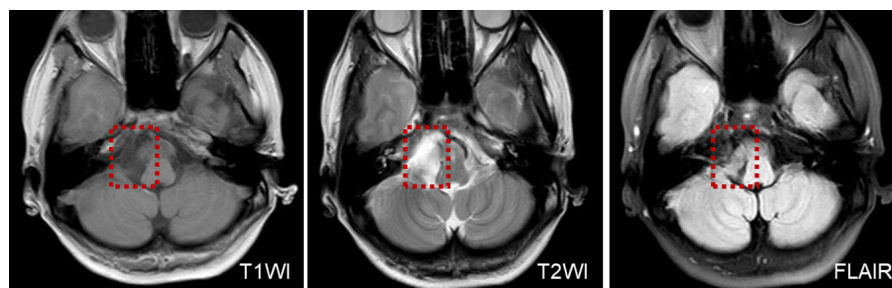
MRI shows low T1WI signal intensity and an inhomogeneous texture, in a patient with an epidermoid cyst of the posterior cranial fossa.
